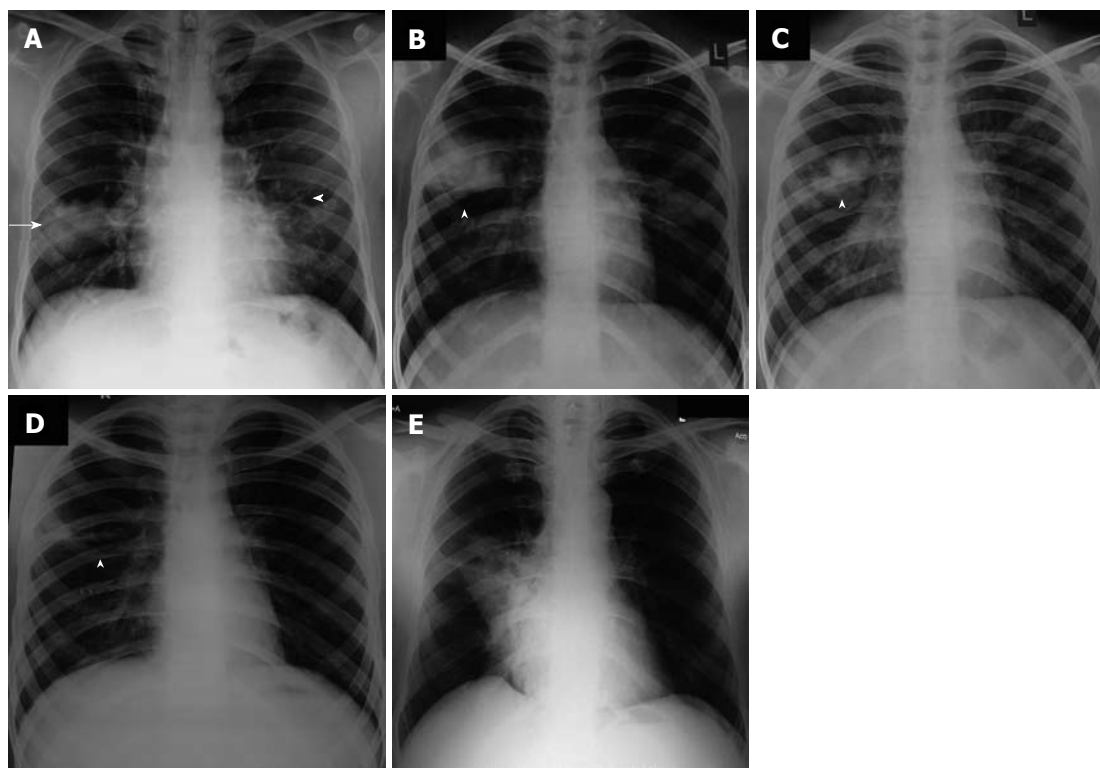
Chest radiograph. A: Chest radiograph showing consolidation (arrow) and tram track opacities (arrowhead); B-D: Chest radiographs performed over time in a patient with allergic bronchopulmonary aspergillosis showing fleeting pulmonary opacities, and clearance after treatment. Arrowheads depict the fleeting opacities; E: Chest radiograph showing subsegmental collapse.
